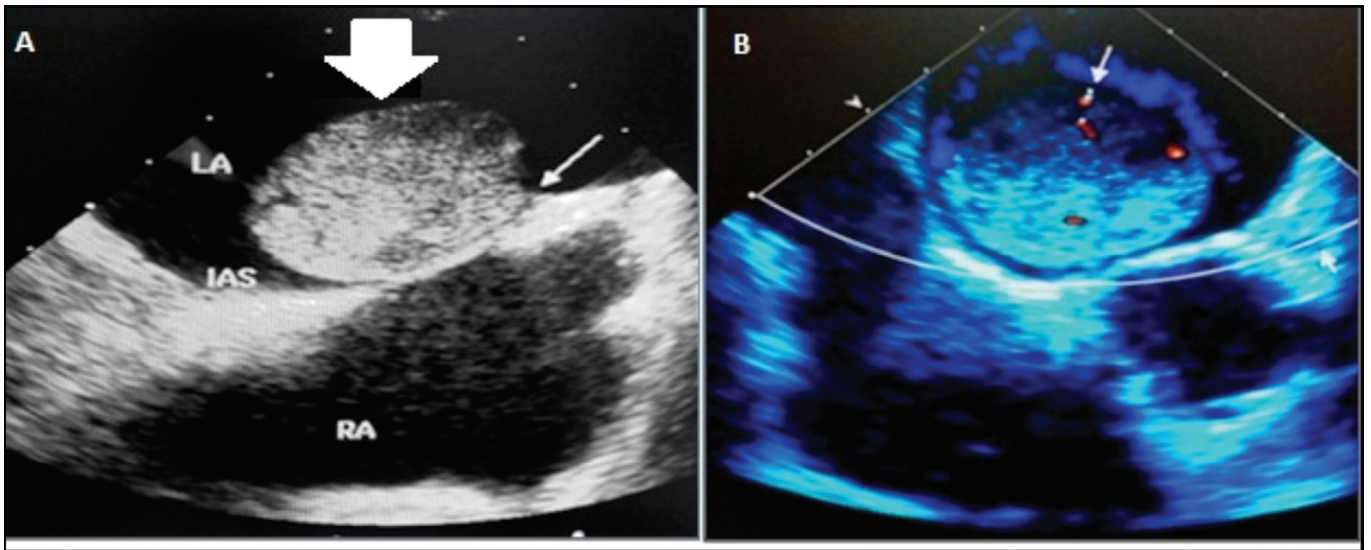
Preoperative transesoophageal echocardiography revealed the mass (A) and its vascularization with color doppler (B). LA indicates left atrium; RA, right atrium; IAS, interatrial septum.
